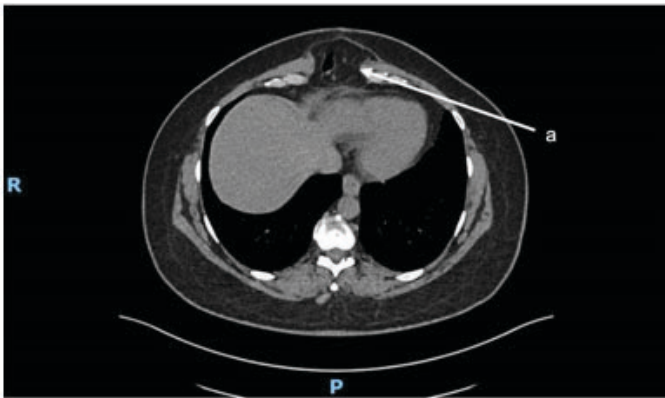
Computed tomography (CT) scan demonstrating epigastric incisional hernia (a).
